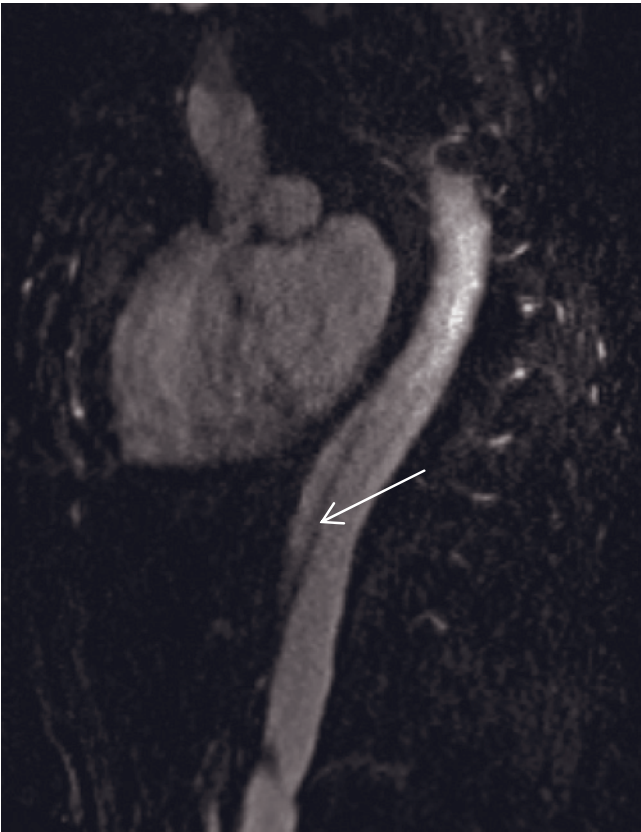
(Continued) T2-weighted true fast imaging with steady-state precession (True-FISP) images demonstrate abdominal aortic aneurysm involving ascending and descending aorta in another patient. Note that the left ventricle wall is hyperthrophied. Sagittal 3D-GE MRA images (*j-l*) and transverse reformatted image (*m*) demonstrate type B dissection in another patient.
